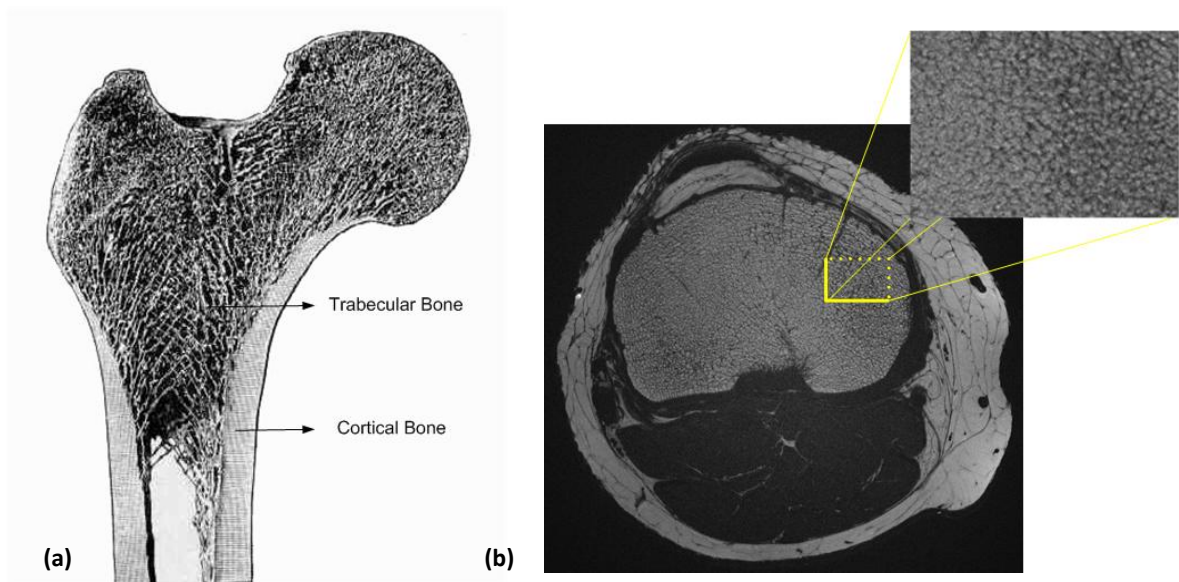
Bone anatomy (a) Coronal plane photo of proximal femur showing cortical bone and trabecular bone. (b) High resolution spin-echo MR image shows the trabecular network by detecting the signal from bone marrow
